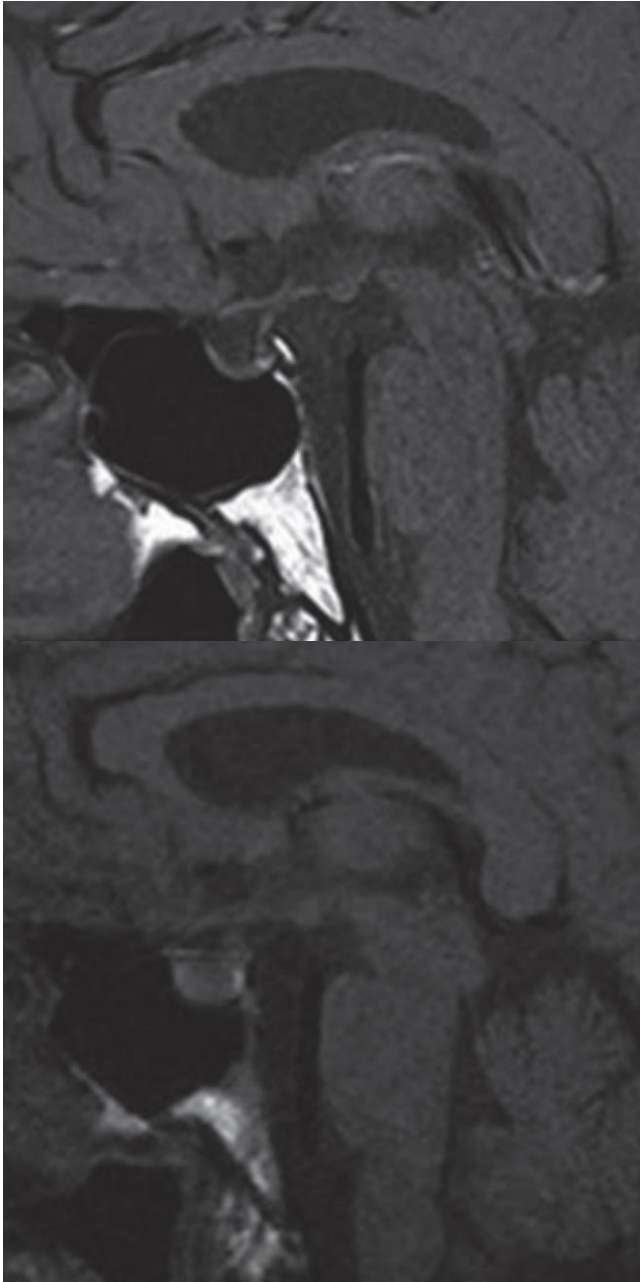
T1-weighted sagittal MRI during the acute phase (a) displays an increased signal intensity in the pituitary gland consistent with hemorrhage. Control MRI (b) shows an atrophic pituitary gland. The sagittal diameter of the pituitary gland had been markedly reduced from 9.1 mm (a) to 1.9 mm (b). Republished with permission of John Wiley and Sons, from (14); permission conveyed through Copyright Clearance Center, Inc.
